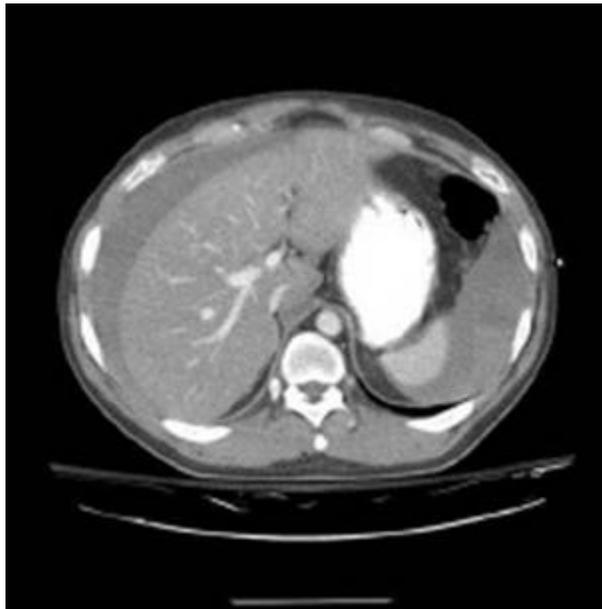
CT scan of a 26-year-old man after a motor vehicle crash shows a significant amount of intra-abdominal bleeding.
